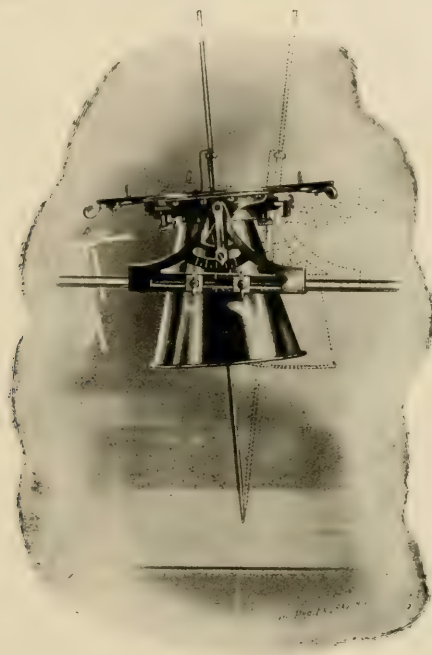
The lead glass bowl and X-ray tube must be removed while the centering rod is being used. When the stand is "set," the rod is removed and the protection bowl and X-ray tube replaced.
